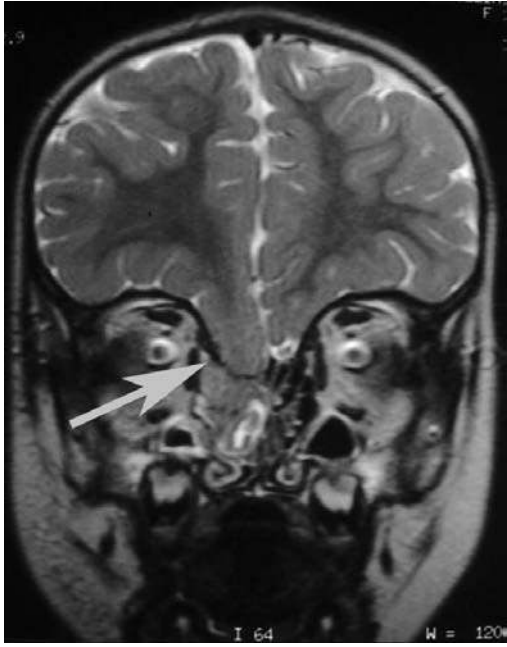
Coronal MRI demonstrates the herniation of the encephalocele through the frontal cribriform plate into the right nasal cavity (arrow).
